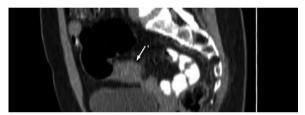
CT of the abdominal cavity of the pelvis without contrast, segmental thickening of the sigmoid colon
